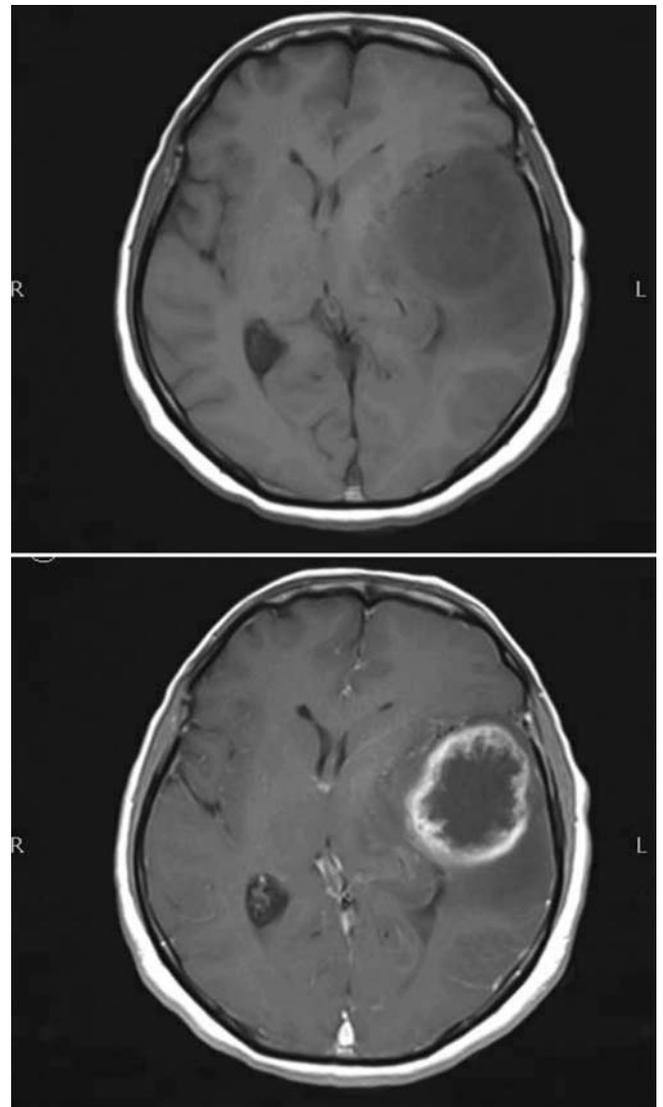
Figure (a & b): MRI axial sections T1WI plain and with contrast, showing typical features of a left temporal lobe glioblastoma multiforme.
